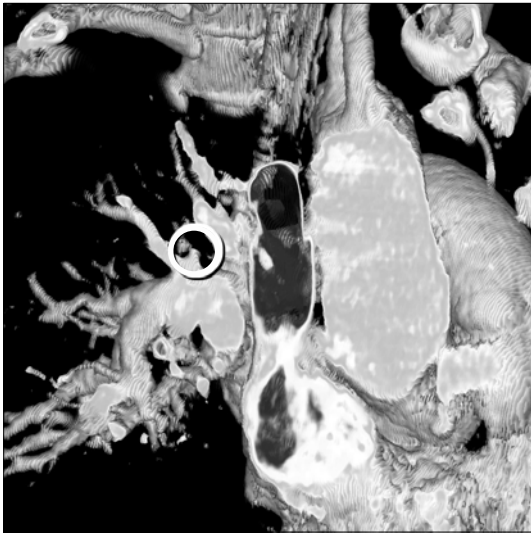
Reconstructed pulmonary embolism CT demonstrated a small sacular aneurysm in proximal portion of the segmental branch, right upper lobar pulmonary artery and diffuse bronchial wall thickening in right main and upper lobar bronchus.
